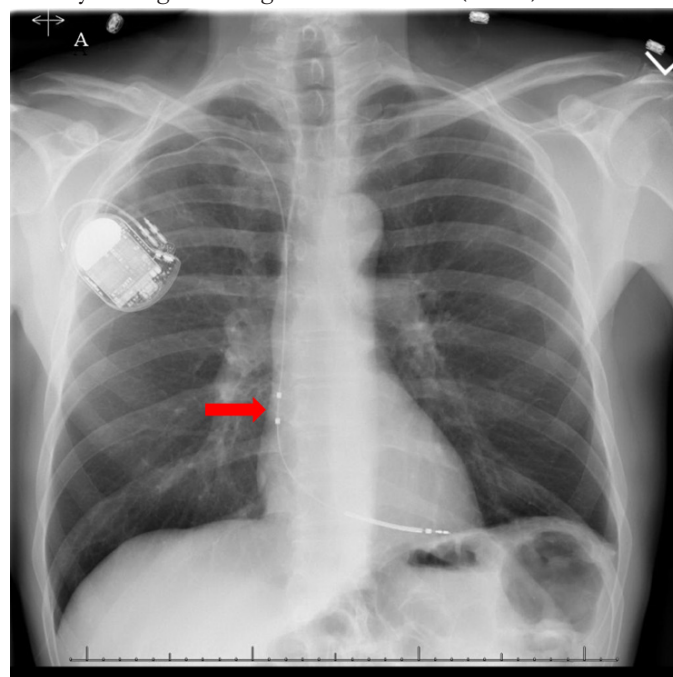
A chest X-ray images showing placement of the Biotronik Linx Smart DX active fixation lead in the apex
